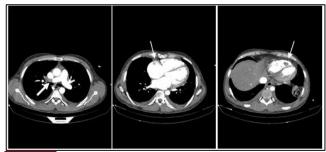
Pulmonary computed tomography angiography of the patient. 1
